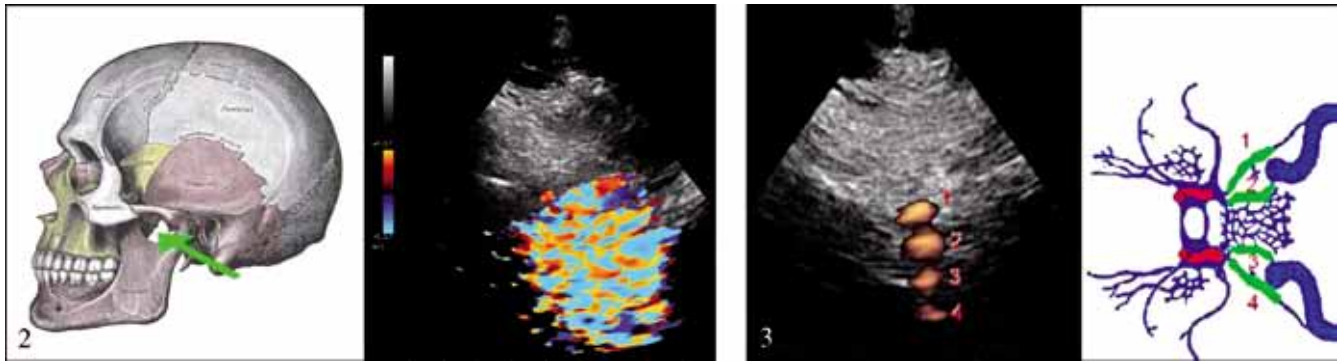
Color cloud artifact marker of the trans-condylar approach. Figura 3.—Visualization of the power Doppler signal through the transcondylar window.
